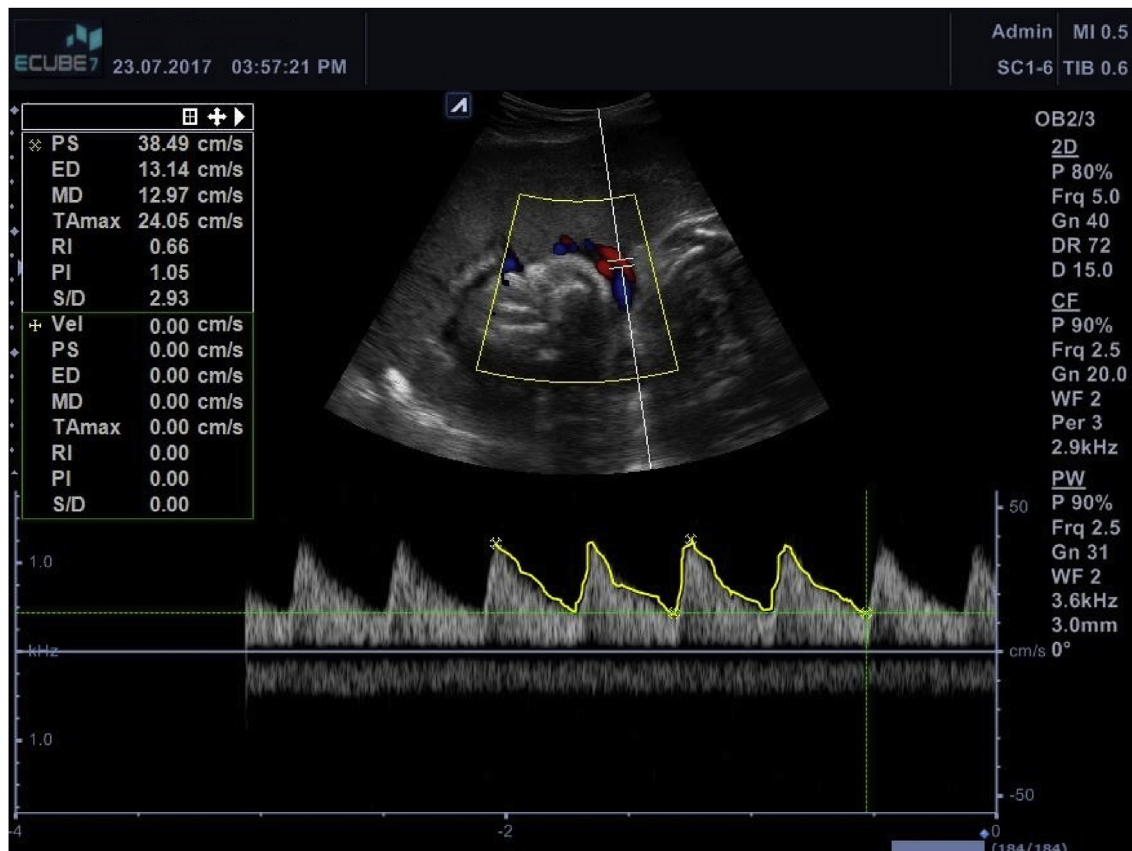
Doppler velocimetry of the UA (PI = 1.05) in a normal singleton pregnancy of 26 weeks' gestation.
